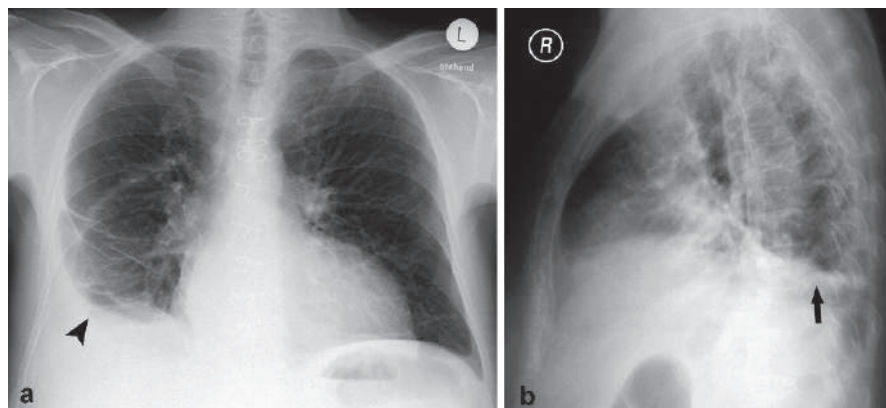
Posteroanterior chest radiograph of a patient with right subpulmonic pleural effusion (SPE) shows raised hemidiaphragm, and the lung seems to end early (arrowhead)
